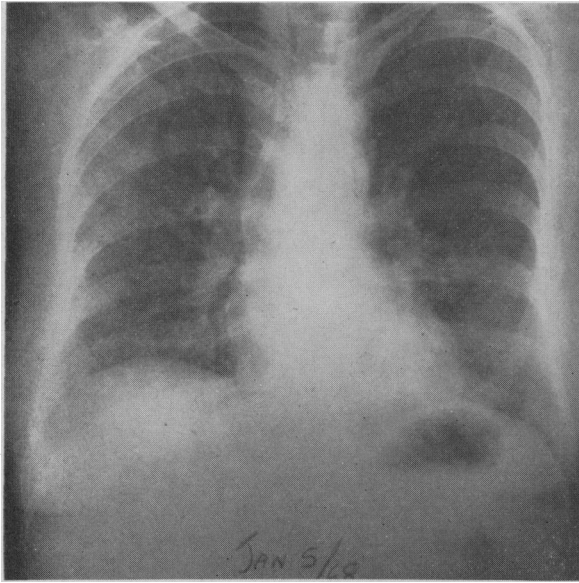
Case 3. Radiograph several years later, after recurrent winter illnesses.
